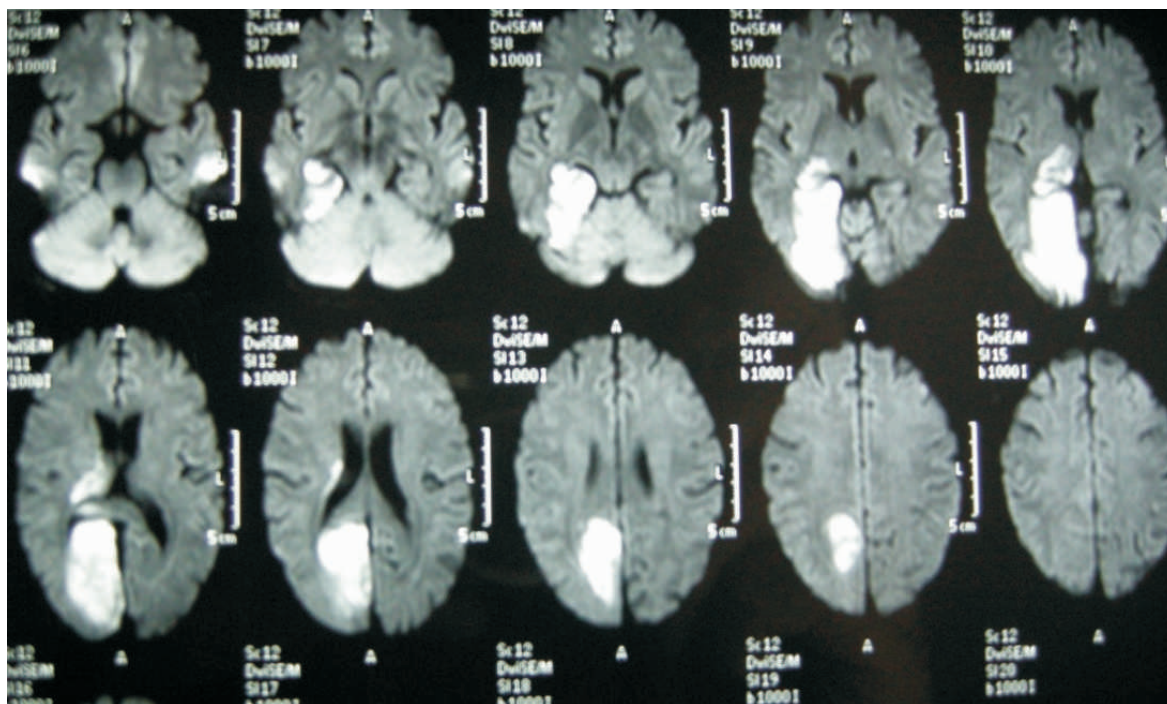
Magnetic Resonance Imaging (MRI) of the client
